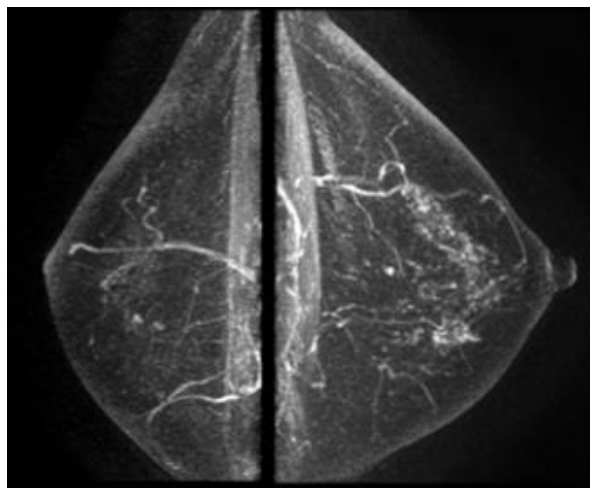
Breast MRI image
